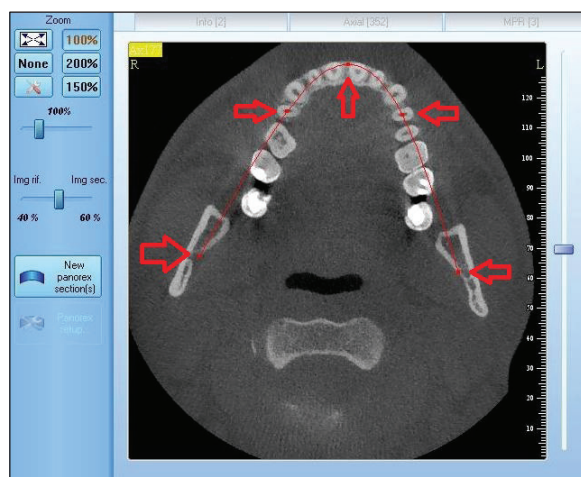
CBCT scan – reference points for the curve.
